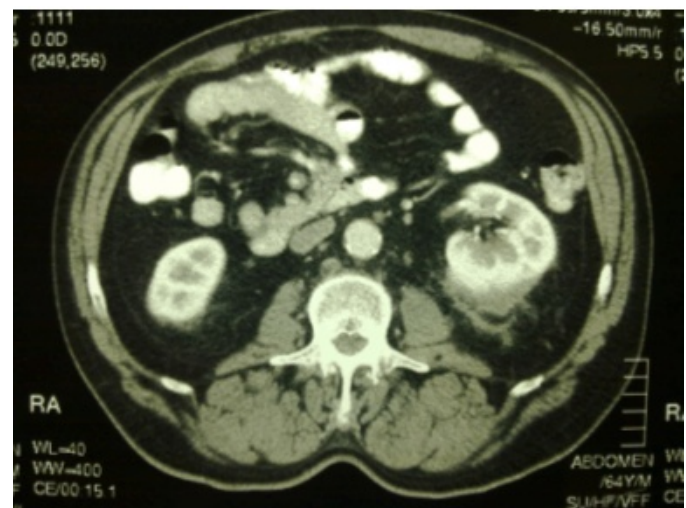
Contrast enhanced CT scan six months later showing almost total dissolution of the hematoma.
